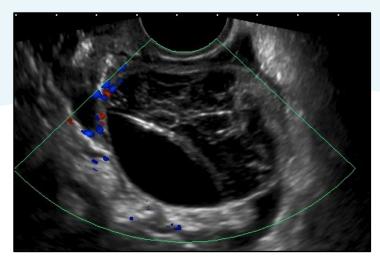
Sagittal ultrasound of right ovary with colour Doppler.
